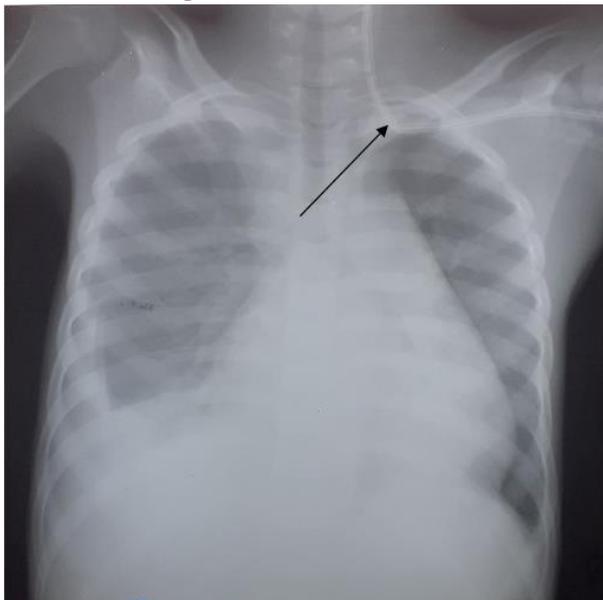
Chest Radiograph showing double lumen central venous catheter inserted by left subclavian vein with the tip reaching the ipsilateral Internal jugular vein (Arrow).
